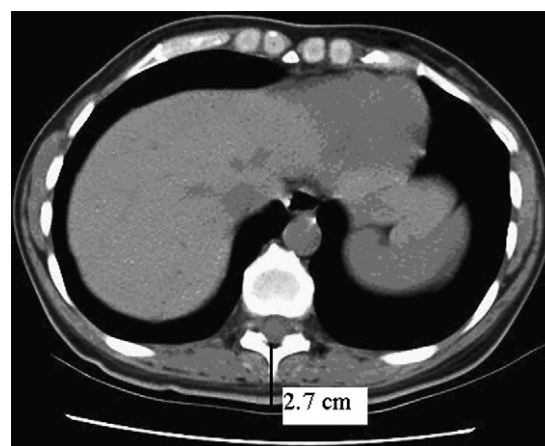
The preoperative CT scan and measured distance (black line) from the skin-to-epidural space at the level of T₁₀ (2.7 cm).
